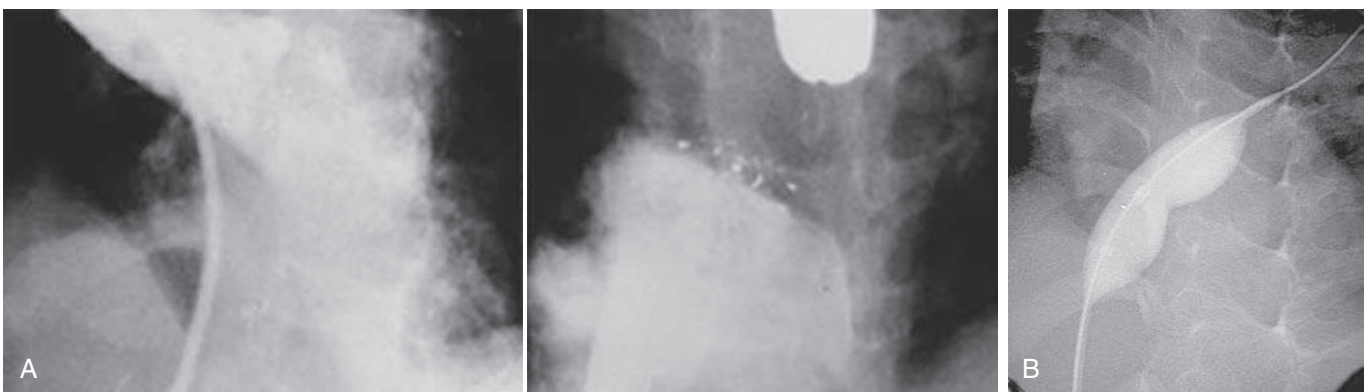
A, Use of angiography for atrial septal defect definition and device placement in the setting of a secundum atrial septal defect has been supplanted by intracardiac and transesophageal techniques. B, However, fluoroscopy is still required for initial device localization, and in many laboratories a short cine-run is done to record the diameter of the static balloon diameter to choose device size. In this case, there is a 30-degree left anterior oblique with 30-degree cranial tilt to best elongate the balloon to avoid foreshortening.
